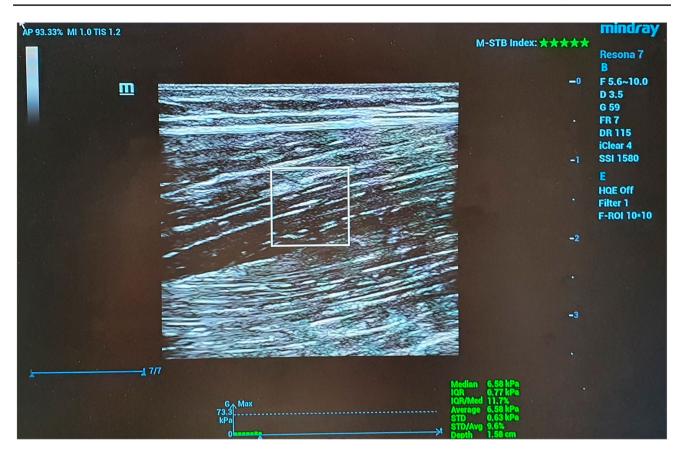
A snapshot of ultrasound measurements
